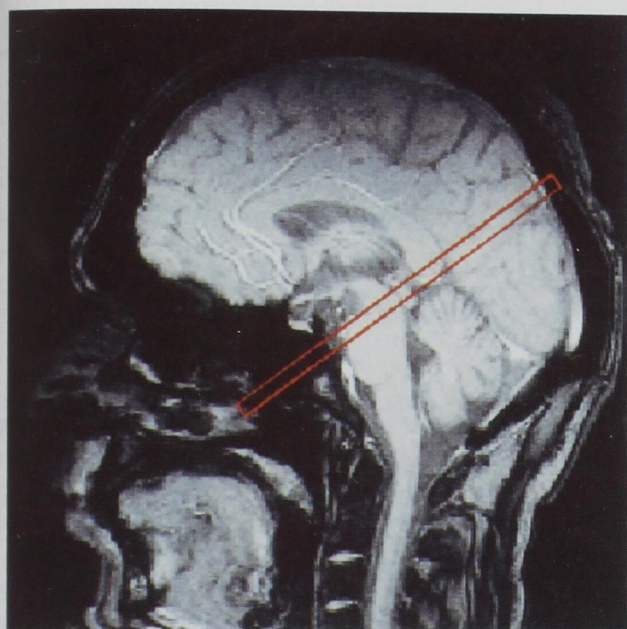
The examination plane for the phase-contrast magnetic resonance imaging perpendicular to the aqueduct of Sylvius is indicated on the Scout image.
